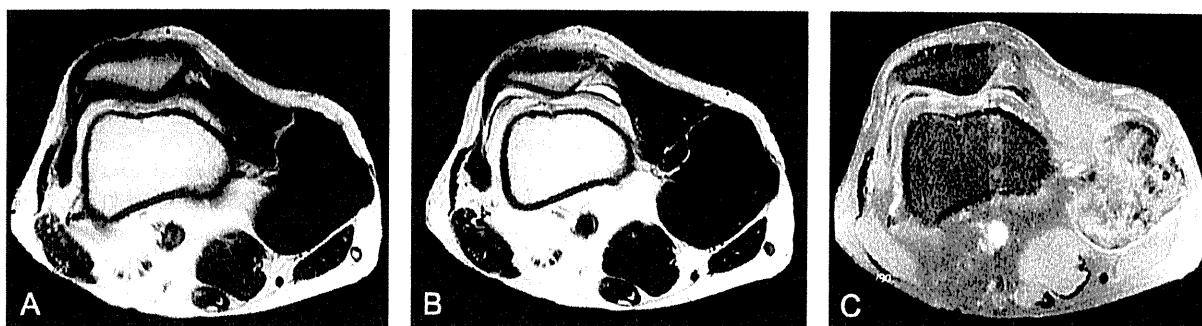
Magnetic resonance imaging findings, April 2002. A) Axial T1-weighted image (TR/TE: 500/8.6) showing an increasing size and the same pattern as one year previously. B) Axial T2-weighted image (TR/TE: 4000/104) showing the same ratio of high signal intensity (SI) area as in previous images. C) Axial postcontrast T1-weighted image (TR/TE: 500/8.6) showing nonenhanced areas that correspond to those showing low SI in precontrast T1-weighted images.
